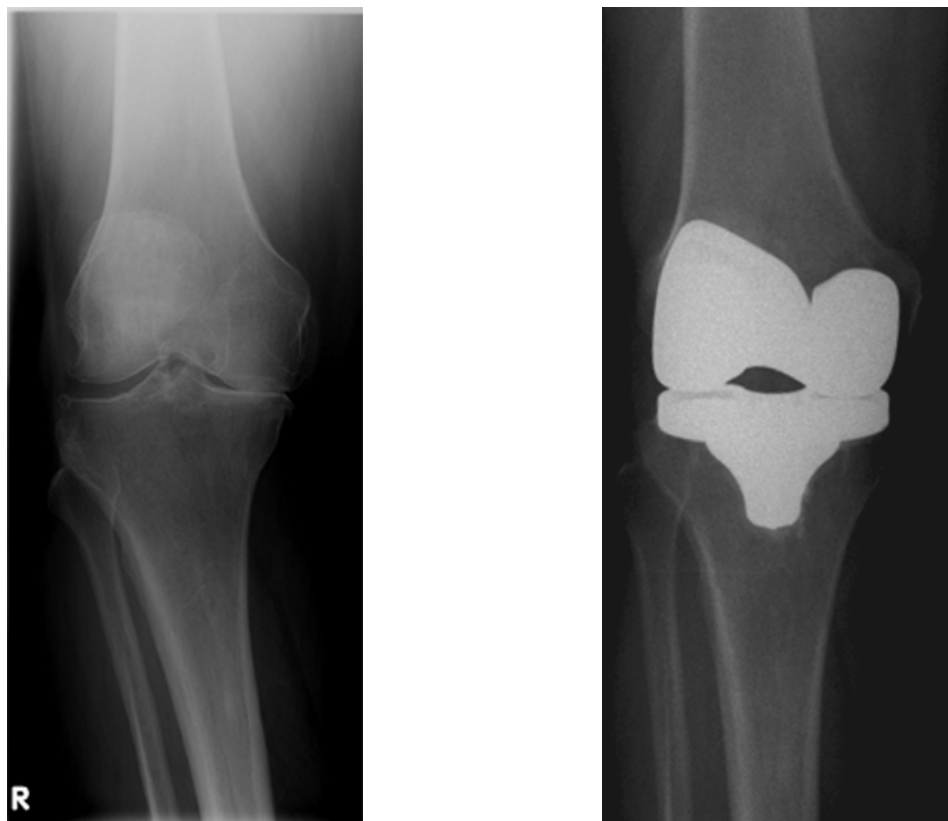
Radiograph of a total knee arthroplasty. Left: Radiograph of severe knee osteoarthritis with varus deformity. Right: Postoperative radiograph of the same knee after replacement with prosthetic components and correction of deformity.
